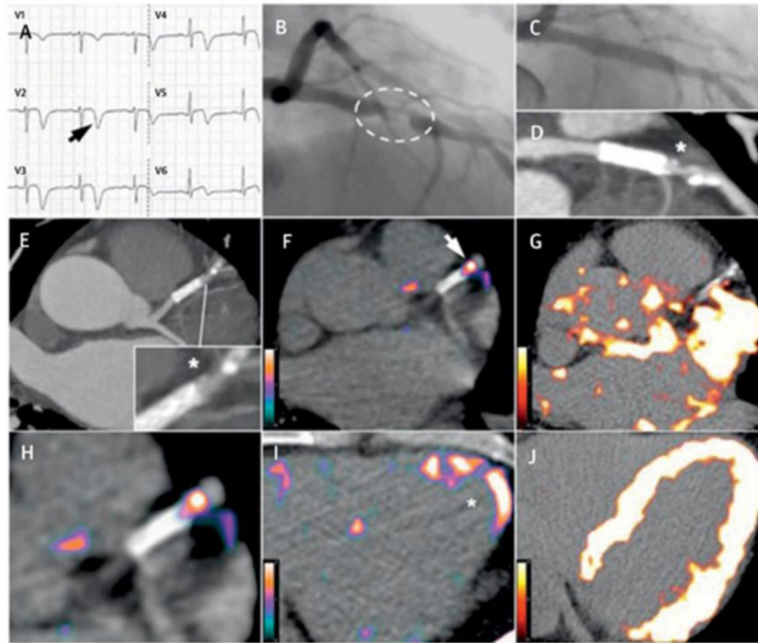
Comparison between ^{68}Ga -DOTATATE and ^{18}F -FDG coronary PET inflammation imaging.
